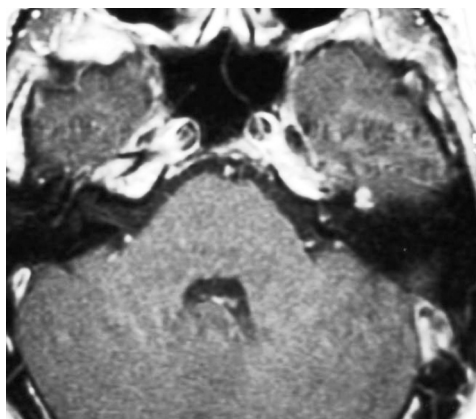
T1-weighted MRI after injection of gadolinium in axial sections. Intense and homogenous enhancement corresponding to the zone of osteolysis seen in the CT-scan.
